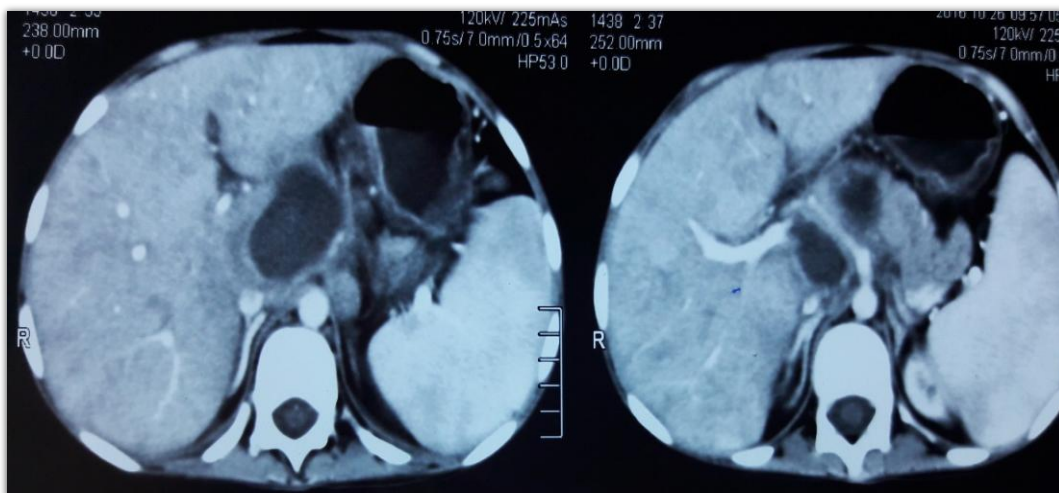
(Axial plane): Abdominal (CT) with IV contrast revealed a mixed mass with mesenteric lymphadenopathy
